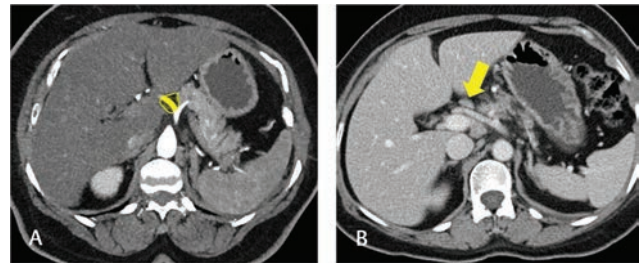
Station 8. Axial CT (A) in arterial phase depicts the station 8 location along the common hepatic artery (yellow area in A). Axial CT (B) in venous phase show station 8 nodes (arrow in B). CT, computed tomography.
